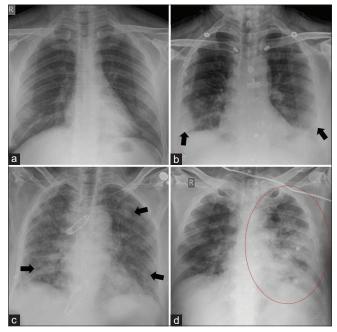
Plain chest radiographic findings different in COVID patients: (a) normal chest X-ray; (b) patchy peripheral and basal ground-glass opacity with increased reticular markings; (c) patchy and ill-defined nodular opacities in bilateral lung fields; (d) diffuse air space opacities with architectural distortion of left lung field
